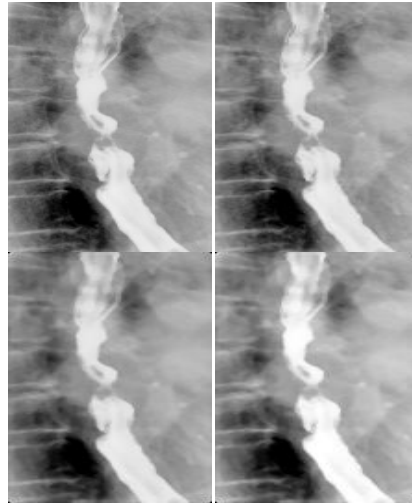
Preprocessing results of constricted esophageal X-ray. Upper left: Original image; Upper right: Color transformed; Lower left: Removed noise; Lower right: Enhanced.
